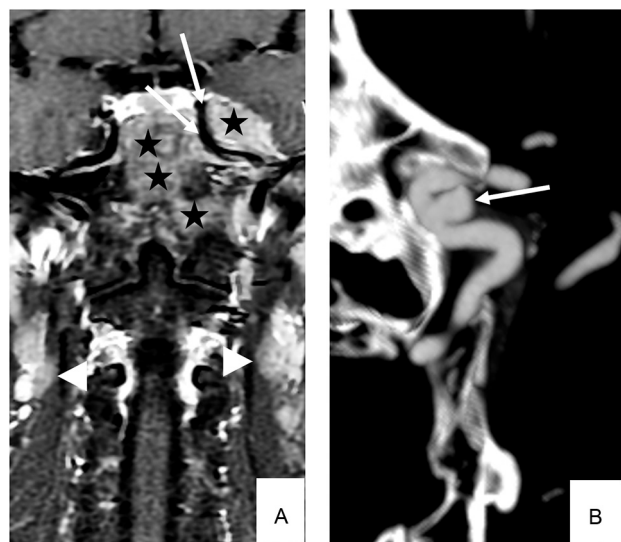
A 52-year-old man with nasopharyngeal cancer (T4N2M0, stage IVA). T1-weighted image (1.5T) with contrast shows that the tumor (A, black stars) has grown into the skull base and embraces the left ICA (A, white arrows) with swollen lymph nodes bilaterally (A, white arrowhead). Five years after irradiation, the patient presented with headache, and a sidewall aneurysm (5.1mm) was detected at the left ICA using CTA (B, white arrow).
